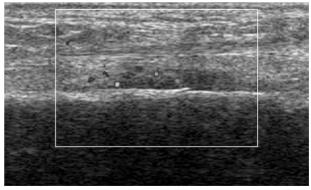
A longitudinal ultrasound image of the second metatarsal bone showed distinct cortical thickening with periosteal hematoma and power Doppler signal.
